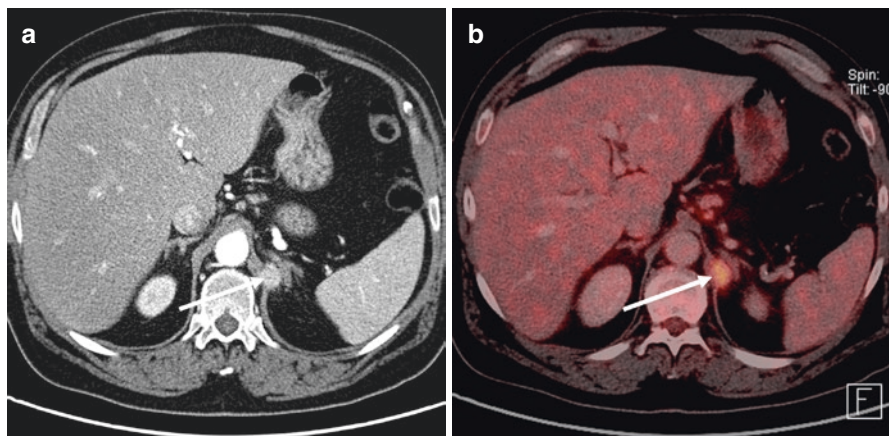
Value of [18F]-FDG-PET/CT in the characterization of a potential distant metastasis. A 53-year-old male patient who had just completed neoadjuvant chemotherapy for locally advanced Barrett carcinoma. On the restaging [18F]-FDG-PET/CT, a new retroperitoneal lesion (a) is seen adjacent to the left adrenal gland. Pathologic FDG uptake (b) confirms this as a new distant lymph node metastasis (alternatively, peritoneal implant), which changed the clinical stage to stage IV. No surgical resection was performed, the patient continued on palliative medical therapy
